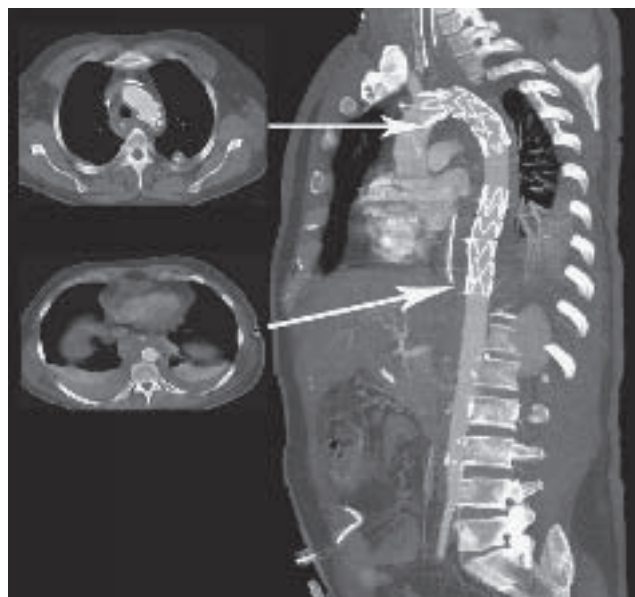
Same patient as in Fig. 1 after immediate sequential implantation of two Relay® stent grafts. The distal stent graft was implanted first, which resulted in immediate hemodynamic stabilization. Sagittal CT reconstruction on the third postoperative day. The stent graft at the isthmus is oversized by 30% and is bulging into the spot of the rupture. CT scan of stent graft at the diaphragm showing residual hematoma but complete sealing of the lesion.
